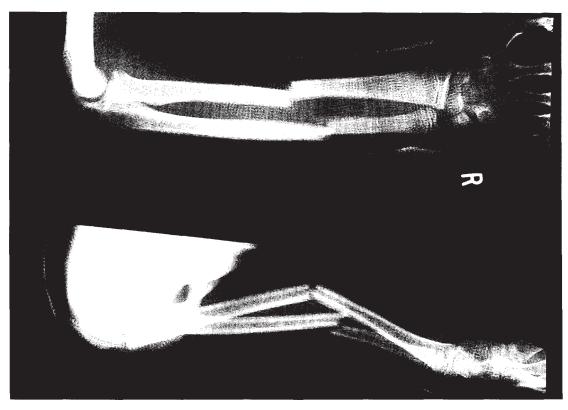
X-ray showing a closed fracture of both forearm bones with displacement within the cast.
